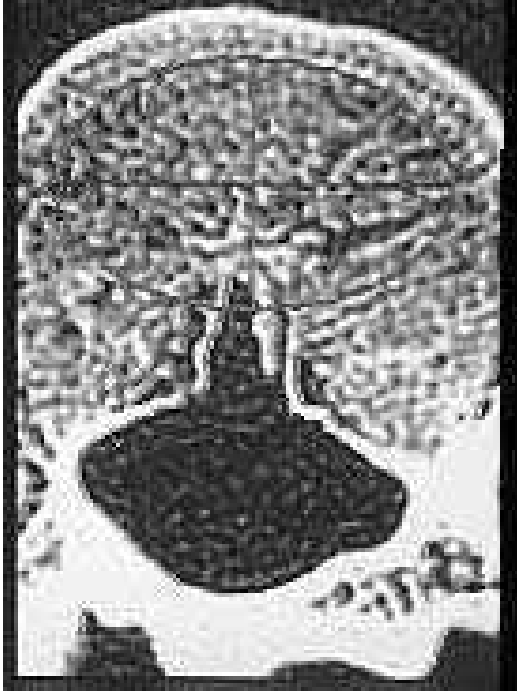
CT image of a human vertebral body where the trabeculae are well identifiable. (Courtesy G. Guglielmi — IRCCS *Casa Sollievo della Sofferenza*, S. Giovanni Rotondo, Italy).
